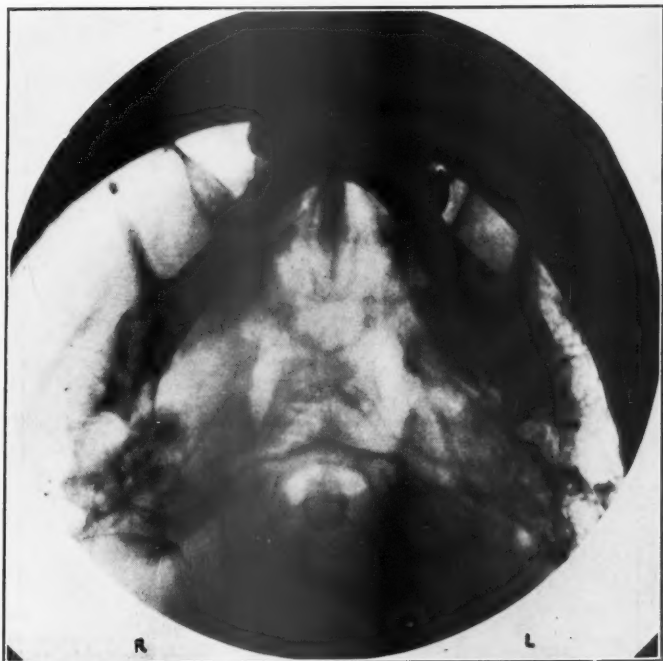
Case 8. This radiograph was made by Dr. Frederick M. Law. The left pyramid is clearly shown and is pneumatized to the tip; it shows normal aeration. On the right side the tip shows intense atrophy, with complete loss of trabeculation.
